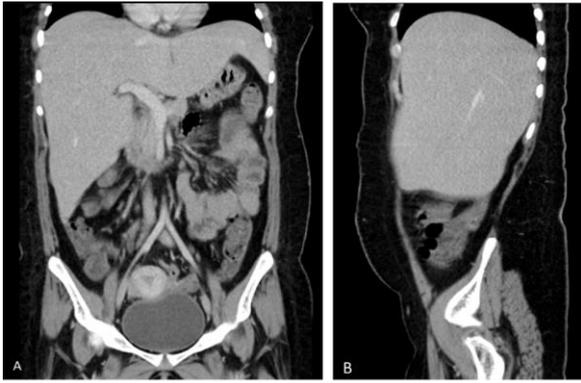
CT for the abdomen and pelvis in Coronal (A) and Sagittal (B) planes, shows mild hepatomegaly
